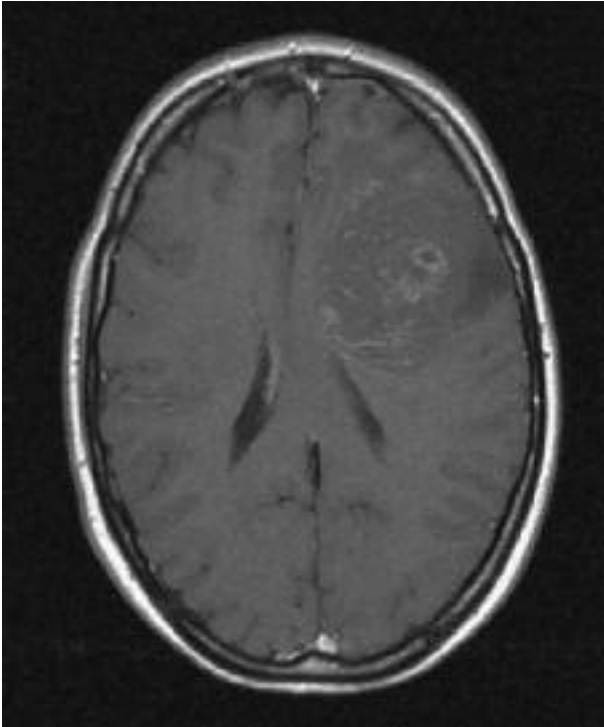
T1 weighted MRI with contrast injection before treatment, showing, in the left frontoparietal region, a partly enhancing mass with a focal ring-shaped enhancement, suggestive of high grade glioma with focal necrosis.
